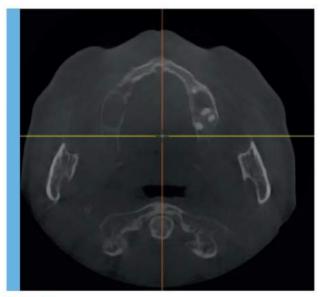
CT cross-section before the bone grafting.
